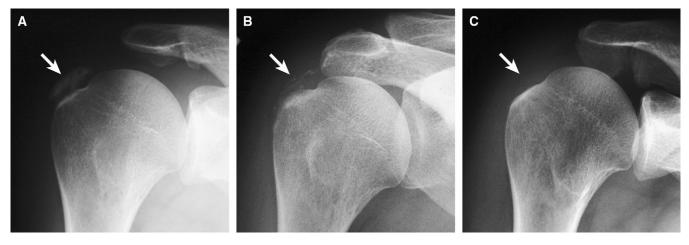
A 57-year-old man with improved symptoms after ultrasound-guided percutaneous needle aspiration. Radiographs obtained (A) before treatment, (B) 2 months after treatment, and (C) 1 year after treatment show radiographic resolution of supraspinatus calcific tendinitis (arrows).
